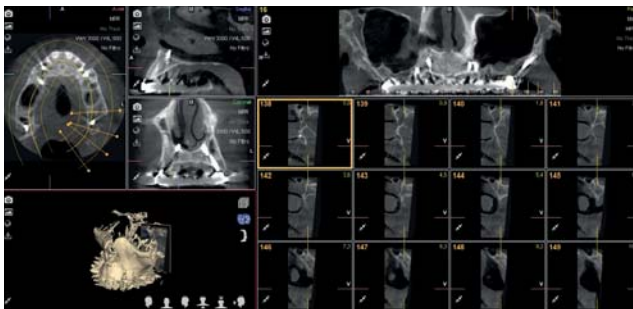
CT scan with panoramic image showing pterygoid on the left side.
